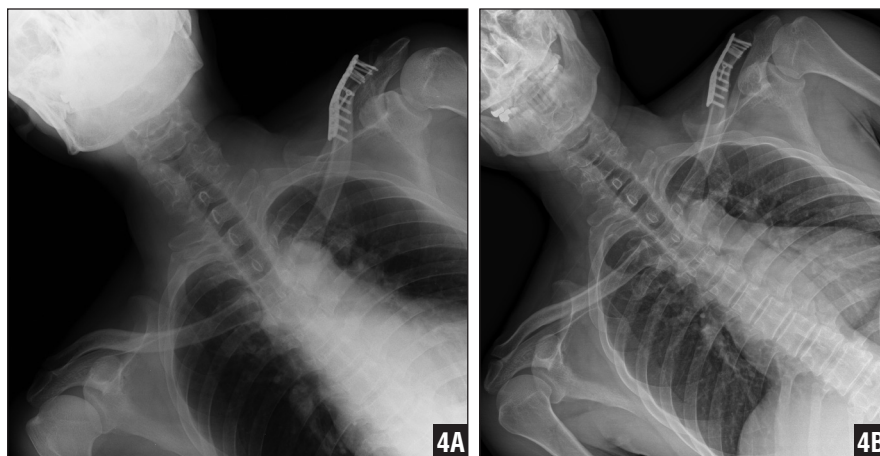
Radiograph of a 49-year-old man with a left distal clavicle fracture shows coracoclavicular distance similar to that of the right shoulder (A) in the immediate postoperative period (B) at final follow-up.
